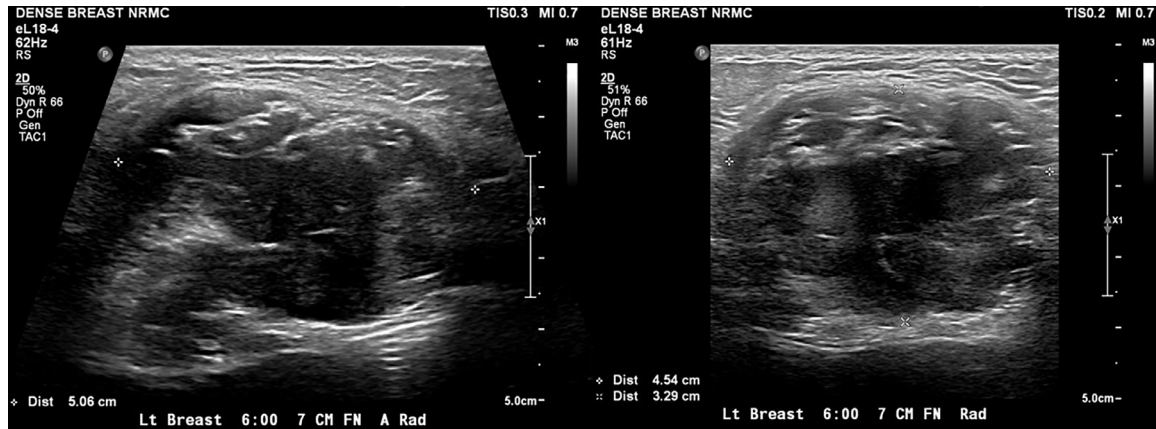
Anti-radial and radial ultrasound images of a mass in the left breast at 6 o'clock 7 cm from the nipple. The mass measures 5.1 × 4.5 × 3.3 cm and is irregular and hypoechoic with indistinct margins.
